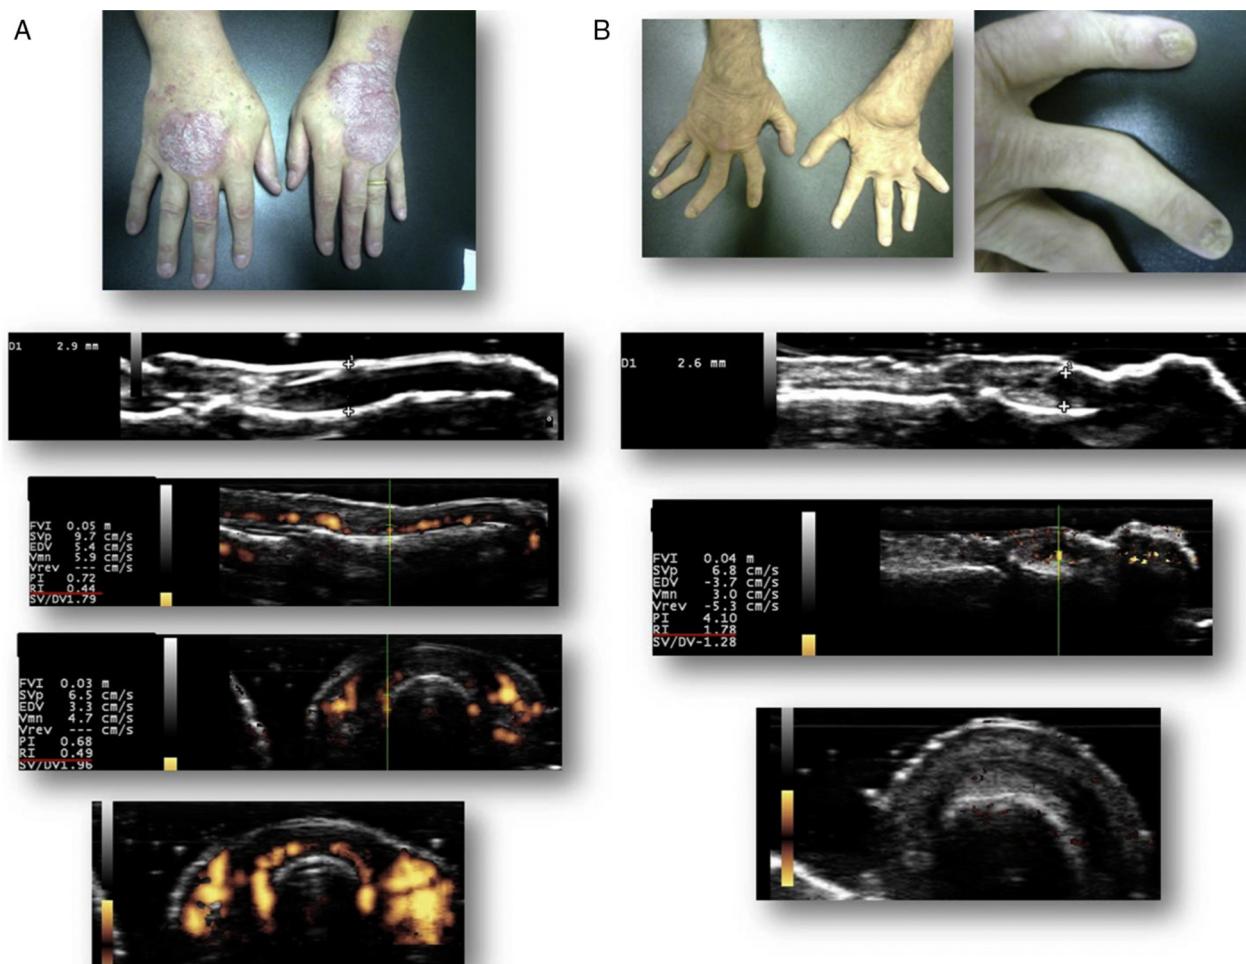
A, Patient with psoriatic arthritis, with no nail abnormalities in the clinical examination. B, Patient with onychomycosis and rheumatoid arthritis. Both figures depict the evaluation, at nail entheses, through the resistance index (RI) and spectral Doppler (SDoppler), and echotextural changes through grayscale (GS) analysis (longitudinal and transverse planes).
